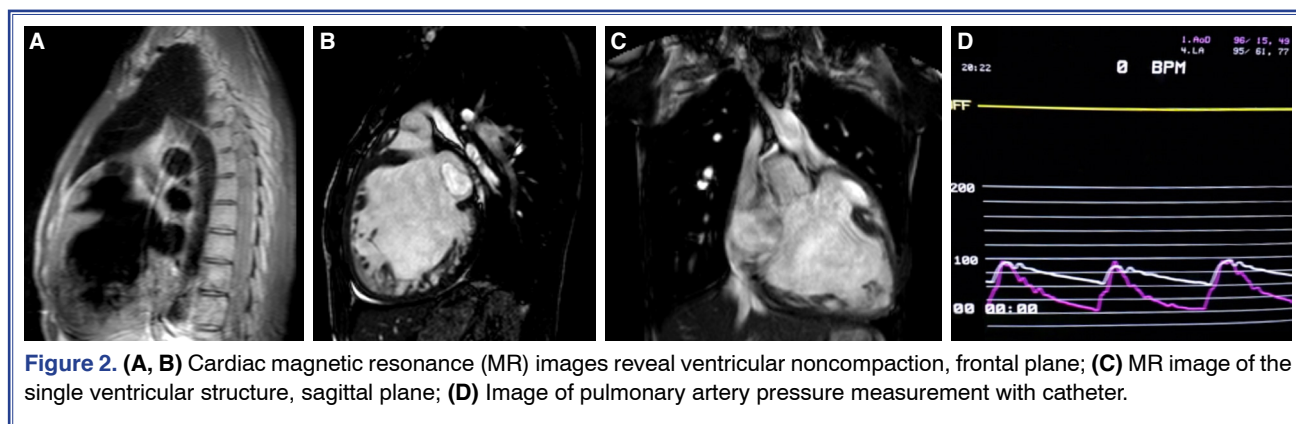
(A, B) Cardiac magnetic resonance (MR) images reveal ventricular noncompaction, frontal plane; (C) MR image of the single ventricular structure, sagittal plane; (D) Image of pulmonary artery pressure measurement with catheter.
